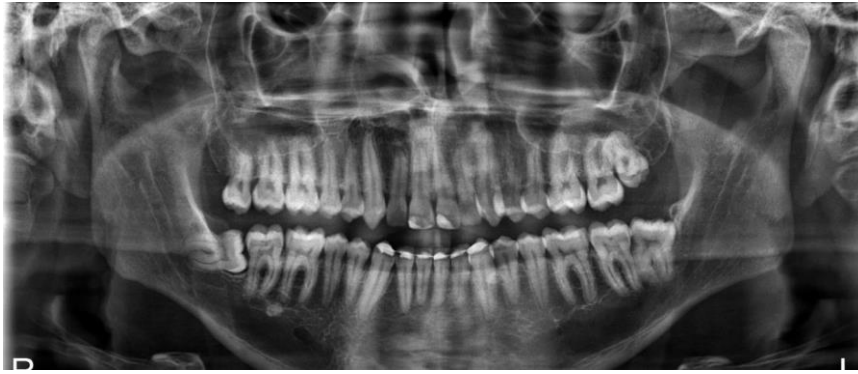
Preoperative panoramic radiograph for lower and upper right third molar surgery.
